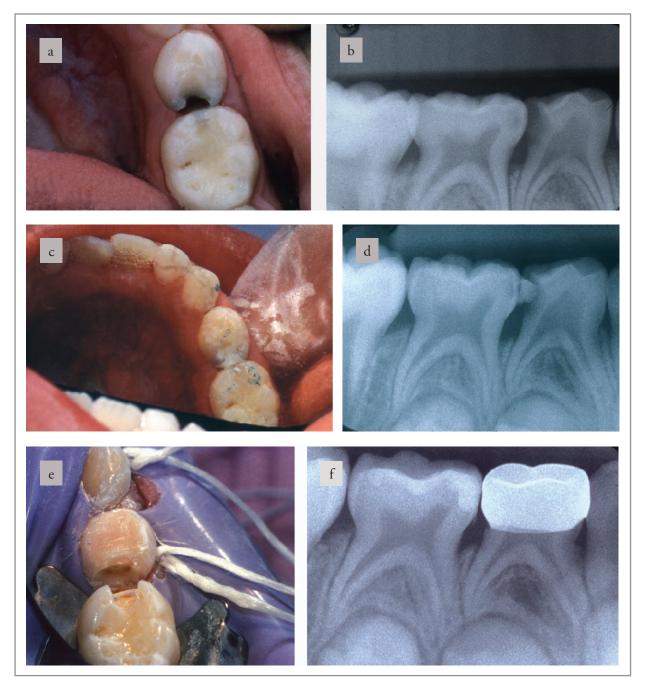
Example of using glass ionomer caries control to diagnose reversible pulpitis or food impaction in a mandibular first primary molar with a history of pain to chewing sweets and solid foods for 2–3 weeks. (a) Preoperative view. (b) Preoperative radiograph. (c) View immediately after glass ionomer placement. (d) Two months after caries control. Pain stopped from day glass ionomer placed. No clinical or radiographic sign of irreversible pulpitis. (e) View of IPT with a glass ionomer base. (f) Tooth 16 months after treatment without signs of pain or irreversible pulpitis clinically or on the radiograph.
